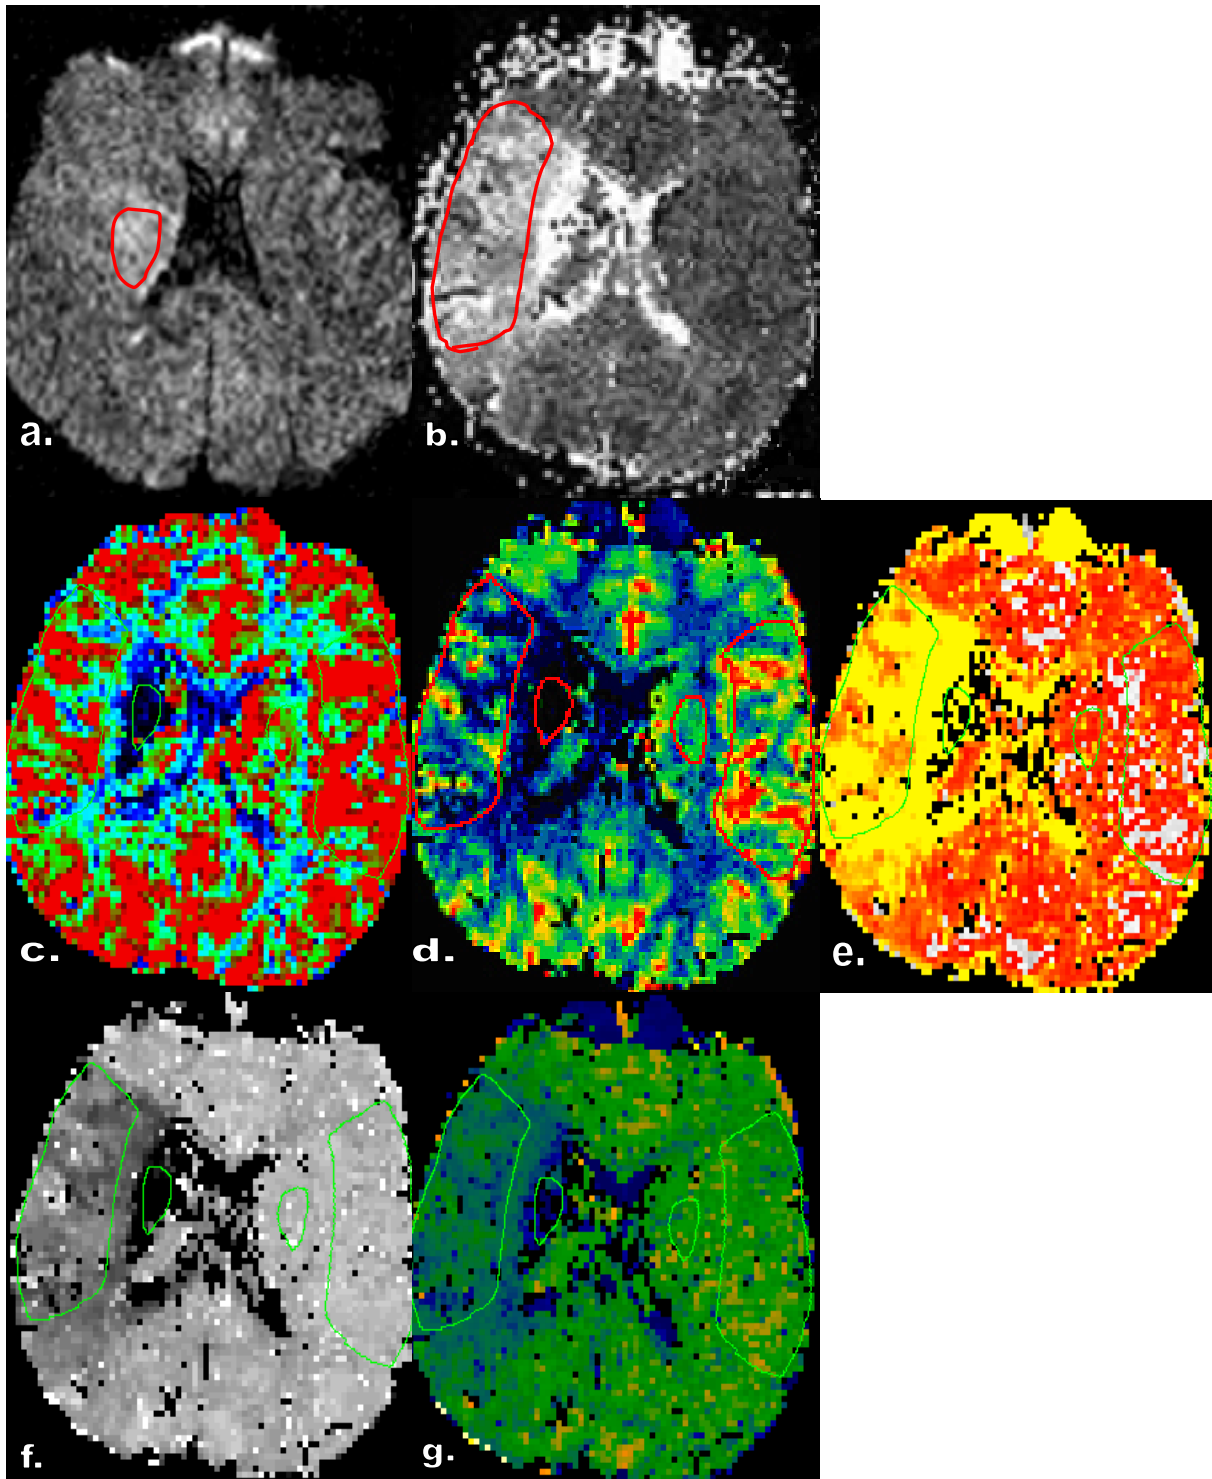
K. R. Male, 61. Left hemiparesis. Ischemia on right MCA territory. NIHSS score was 12. The immediate study (4 hours after onset) showed an ischemia with a large DWI-PWI mismatch in the right MCA territory. Volume ratio was greater than 1/3. The ROIs for the hemodynamic parameters were drawn on ischemic core and the mismatch region, and on the normal mirror region. Patient received systemic thrombolysis and mechanical recanalization. Patient deceased in the course of the disease (MRS=6). a. DWI showed relative small hyperintensive abnormality, while b. PWI showed larger hypertensive abnormality. c. CBV map, rCBV decreased by 89.4% in core and 44.5% in mismatch. d.CBF map. rCBF decreased by 97.4% in core and 63.3% in mismatch region; e. MTT map. MTT prolonged 24.1s in core and 12.3s in mismatch region; f. TTP map. and g. T0 map. TTP shortened 32.2 s and 7.6 s in core and mismatch region, T0 shortened 22.6 s and 6.4 s in core and mismatch region correspondingly.
